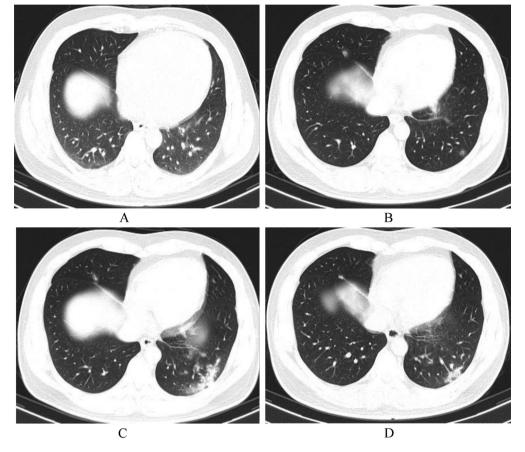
A 35-year-old male who had fever for 2 days. A, CT scan examination was conducted on January 23, 2020. Chest CT scan examination showed no abnormality; B, after 3 days, the CT scan examination showed the mixed grinding glass conjunctivation in the mid-lobe of the right lung and lower lobe of the left lung; C, on day 11, a follow-up CT scan examination noted that the disease range and density increased and were in the progression phase; D, on day 18, a follow-up CT scan examination showed the lesions had decreased, fibrotic lesions appeared and were in the repair phase. However, the lesions remained not fully absorbed.
